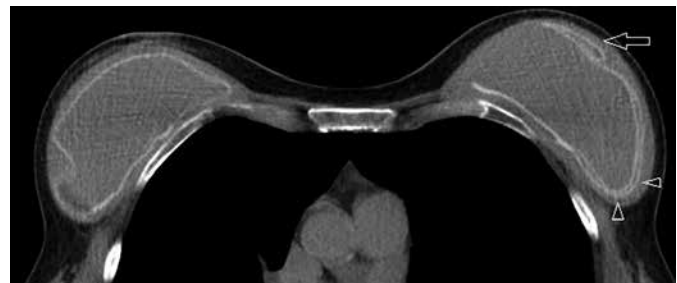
Axial thorax CT section. Sig of the "lock" (arrow), sign of the "subcapsular line" (arrow heads).
